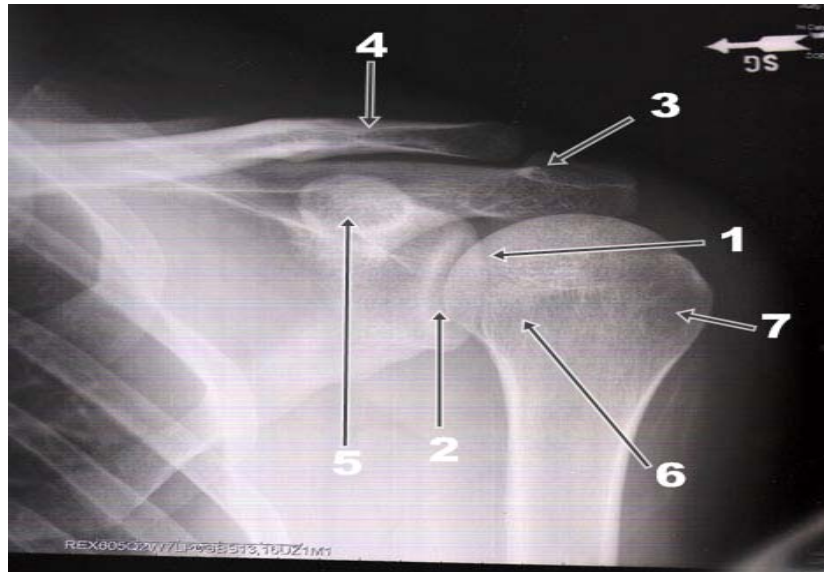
An anteroposterior radiographic view (AP) of a left shoulder joint where the arm is externally rotated showing : 1-Humeral head, 2-Glenoid cavity, 3- Acromion 4-Acromial end of the clavicle, 5-Coracoid process, 6-Lesser tubercle, 7-Greater tubercle of the humerus (American academy of orthopedic surgeons, 2007).
